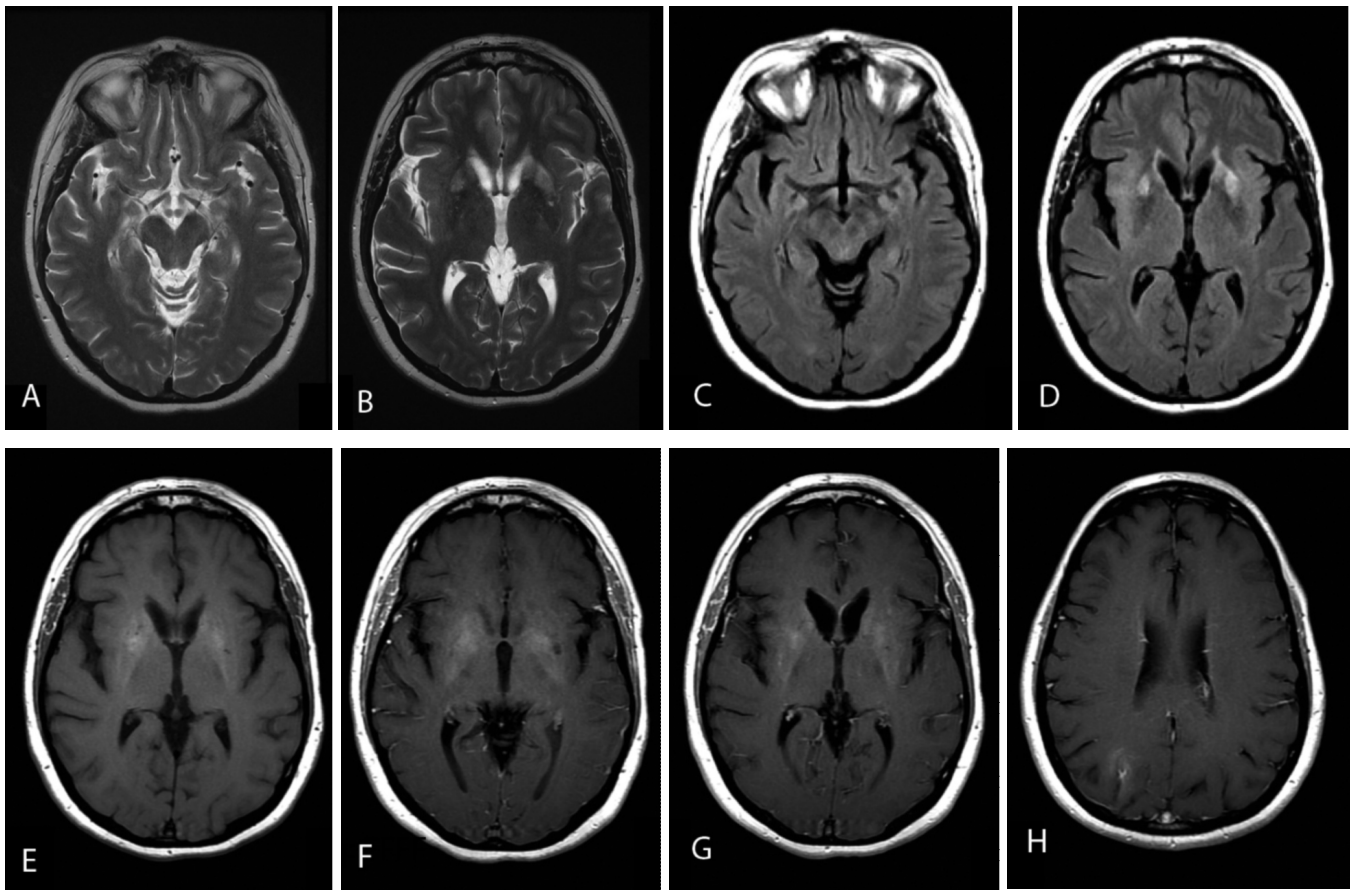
37-year-old female with Hashimoto's encephalopathy. Six-month followup brain MRI. Axial T2 (A and B), axial FLAIR (C and D), axial T1 (E), and axial T1-weighted postcontrast (F, G, and H) weighted images show some improvement with reduction in the extent of the high T2/FLAIR signal lesions in the mesial temporal lobes and basal ganglia, with resolution of gadolinium enhancement. The high T1 precontrast signal in the basal ganglia is now much more evident (E). The left midbrain lesion present in the previous exam is currently not seen.
